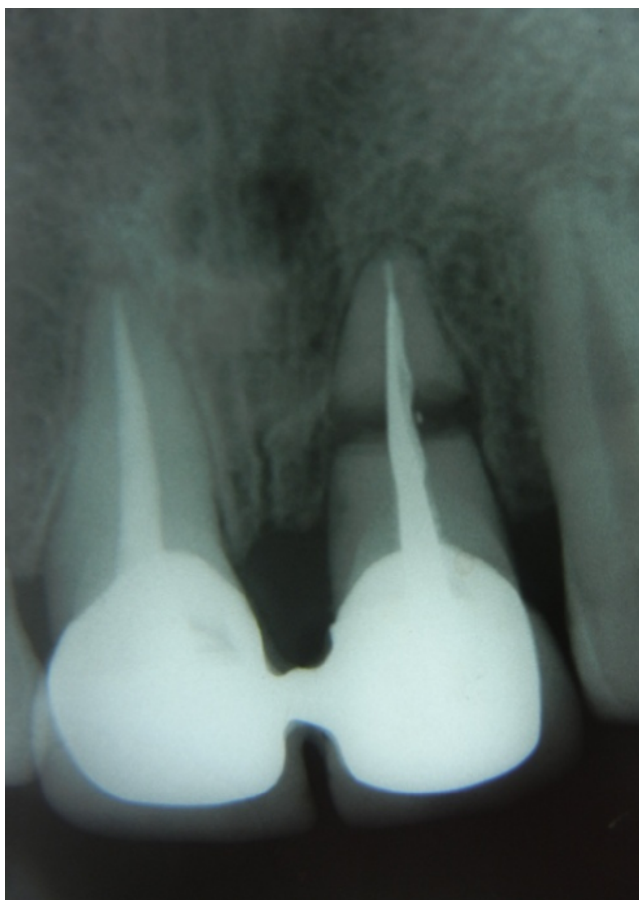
Two year follow-up radiograph.
